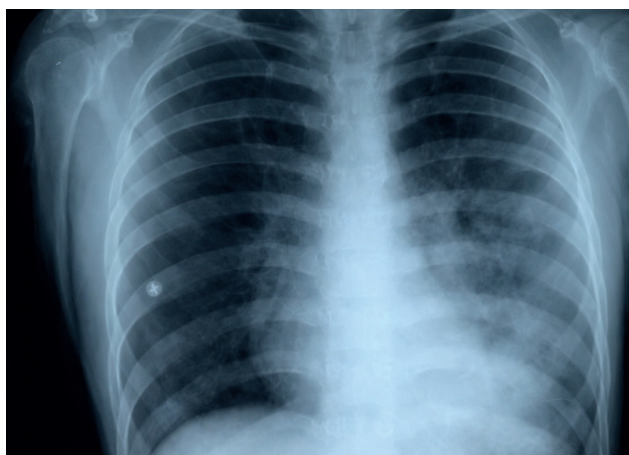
Preoperative patient's chest x-ray. On the left side of the chest the abdominal contents are observed.
